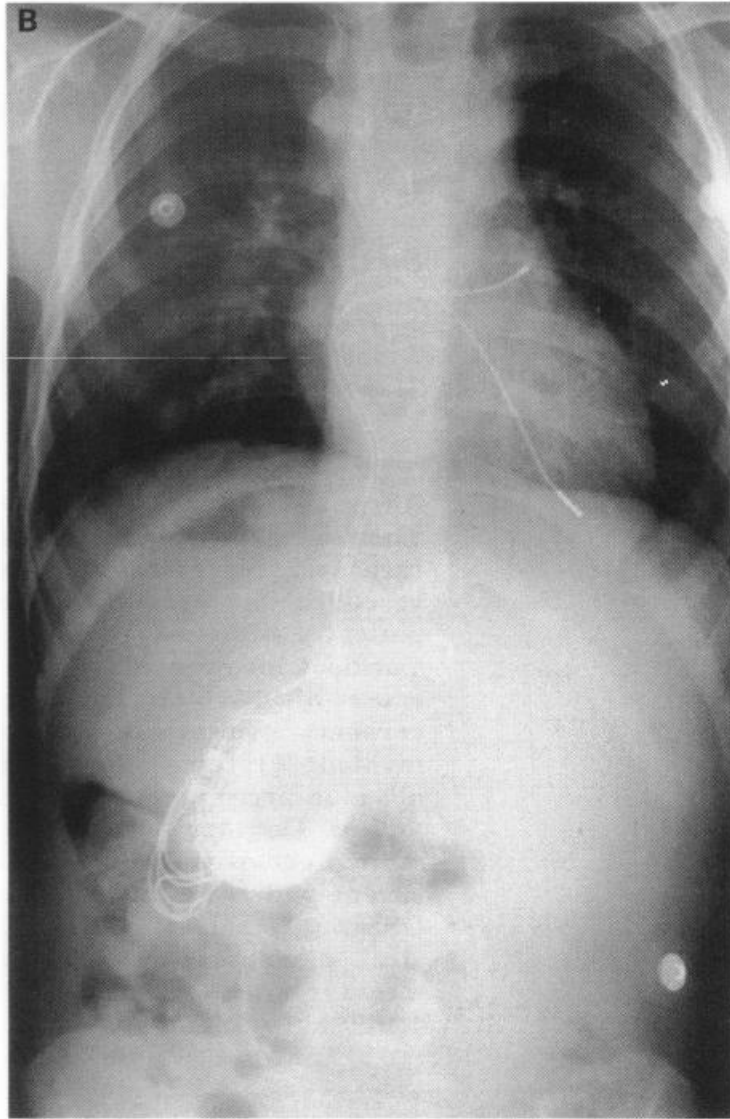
Chest radiographs in posteroanterior (A) and lateral (B) projections, after successful ventricular pacing through the coronary sinus. The redundant epicardial system is still in situ.
